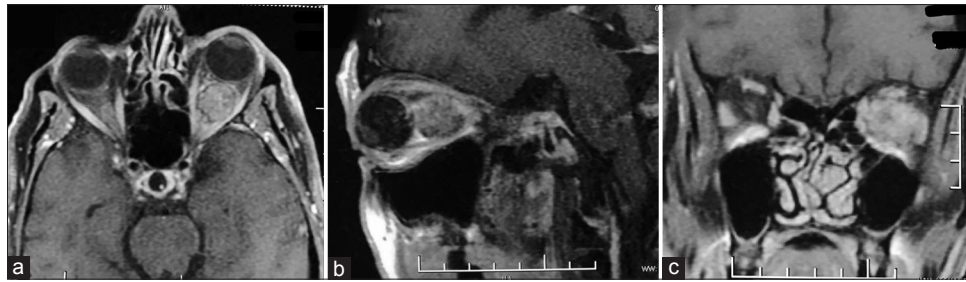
Axial (a), sagittal (b), and coronal (c) contrast magnetic resonance imaging scan showing an intraorbital intraconal tumor in the retrobulbar region. (MRI- Magnetic resonance imaging)
